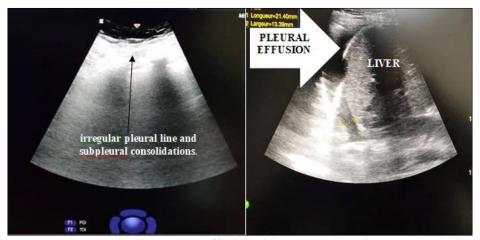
Lung ultrasound demonstrating pleural effusions, irregular pleural line, and subpleural consolidations
